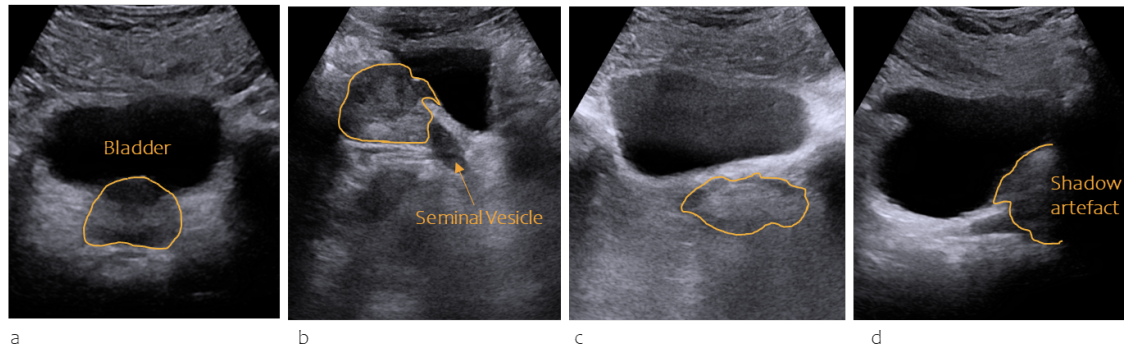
Various presentations of the prostate on transabdominal ultrasound. The prostate is delineated manually with a yellow line. a: The axial imaging-plane, clear visibility of the prostate. The bladder is annotated. b: The sagittal imaging-plane, clear visibility of the prostate with bulging contours that interrupt the bladder. The seminal vesicle is annotated. c: The axial imaging-plane, poor visibility of the prostate due to ambiguous boundaries. d: The sagittal imaging-plane, part of the prostate boundary is invisible due to interrupting acoustic shadow artefacts.
